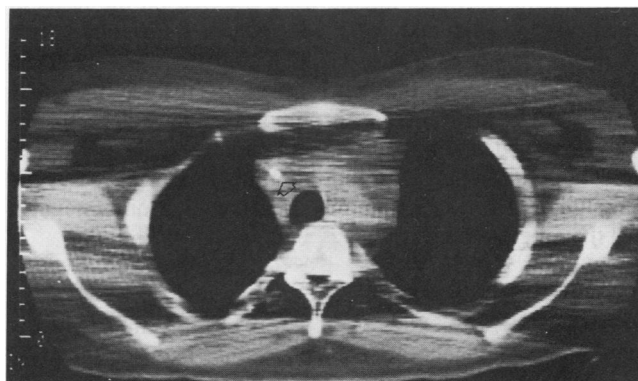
A mediastinal phlegmon in case 2: Computed tomography of the upper mediastinum shows the mediastinal widening and effacement of structural borders typical of a mediastinal phlegmon from catheter-related septic central venous thrombosis. The arrow marks the position of a right internal jugular central venous catheter. Bony artifact is present.
